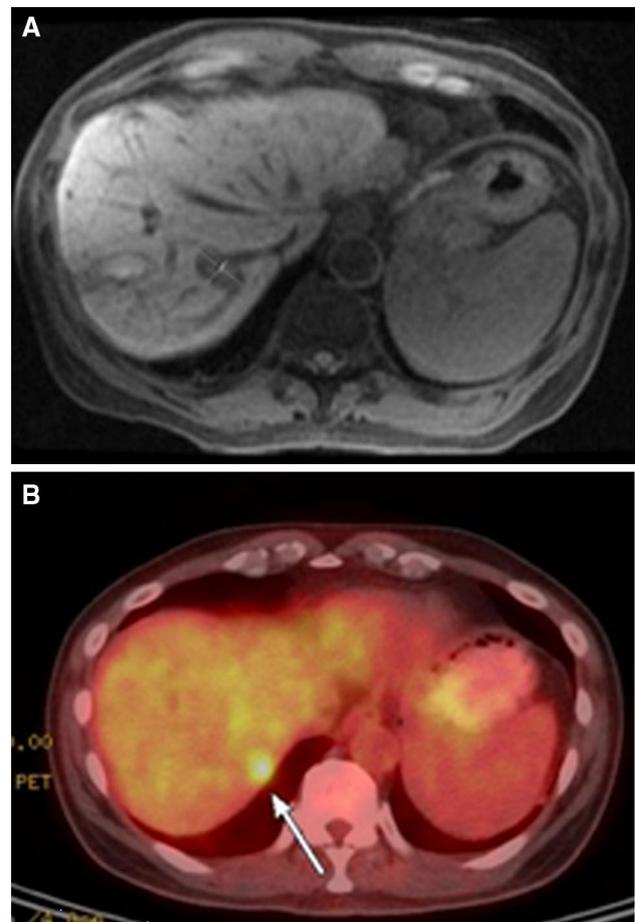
MRI (A) and PET (B) imaging before percutaneous ablation shows one residual lesion in segment 7
